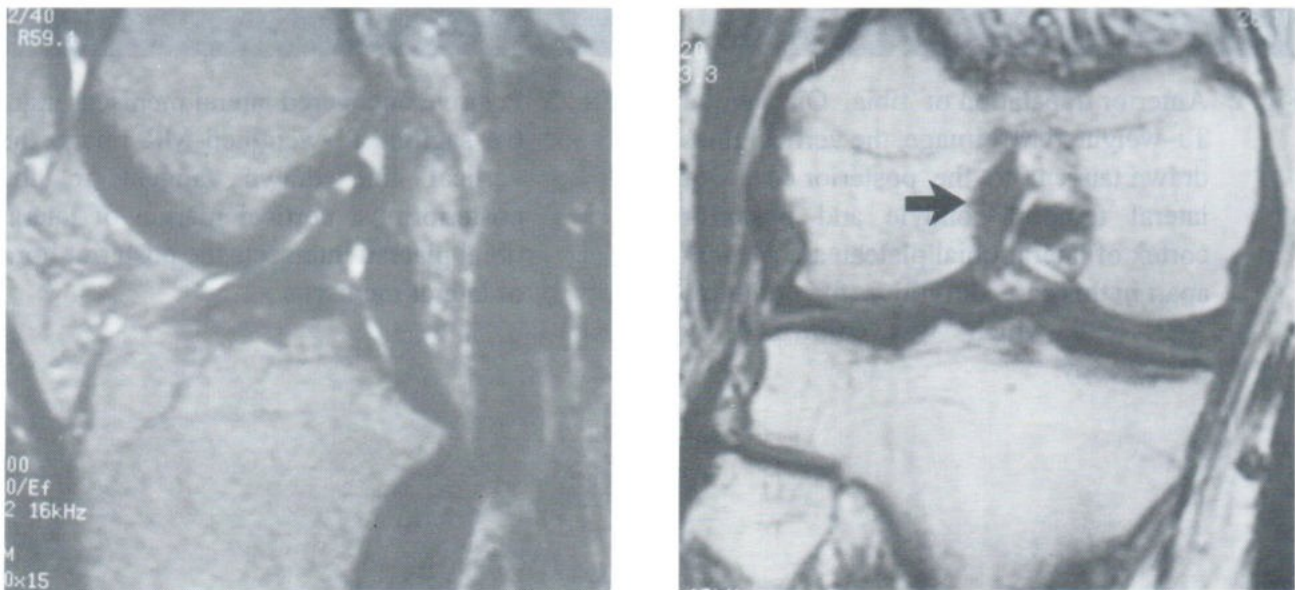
Complete ACL tear. a) Sagittal T2-weighted MR image reveals focally increased SI in the mid portion of ACL. Decreased slope of the ACL is also observed. This is a 26-year-old male athlete presented with history of knee injury for 4 months. b) T1-weighted coronal MR image shows increased SI of the ACL in the intercondylar notch (black arrow). Decreased swelling of the ligament is due to timing of injury.
